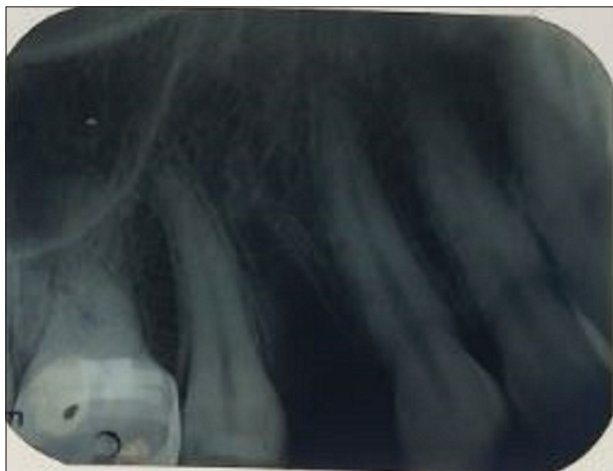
Pre-treatment intraoral periapical radiograph.
